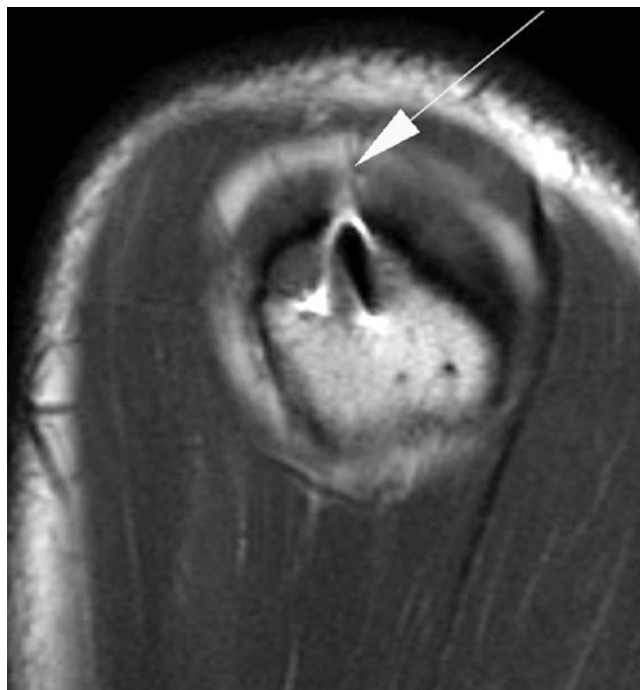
Sagittal oblique T1-weighted image from direct MR arthrogram demonstrates a thin vertical full-thickness cleft (arrow) following rotator cuff repair. This can be a normal finding as the repairs are often not watertight
